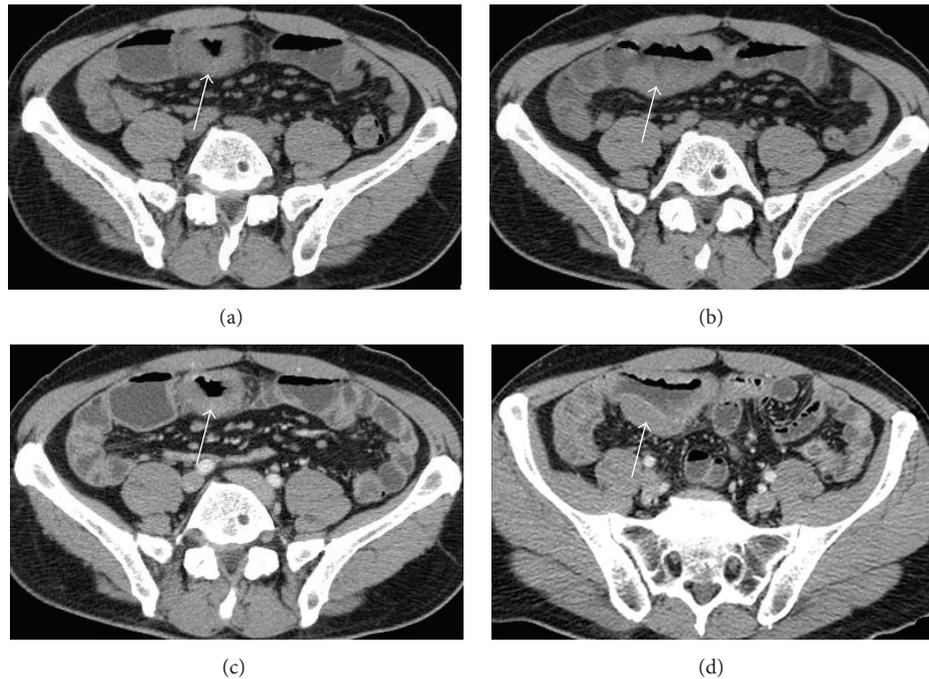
Abdominal CT scan in a 46-year-old male with celiac disease who developed an ileal lymphoma. Abdominal CT scan in the precontrastographic phase ((a) and (b)) and in the postcontrastographic phase ((c) and (d)) shows diffuse segmental (length: 8 cm) wall thickening (thickness: 1,5 cm) (arrows) with mild contrast enhancement in an ileal loop. Multiple subcentimetric lymph nodes are detected near the affected loop in the mesenteric fat.
